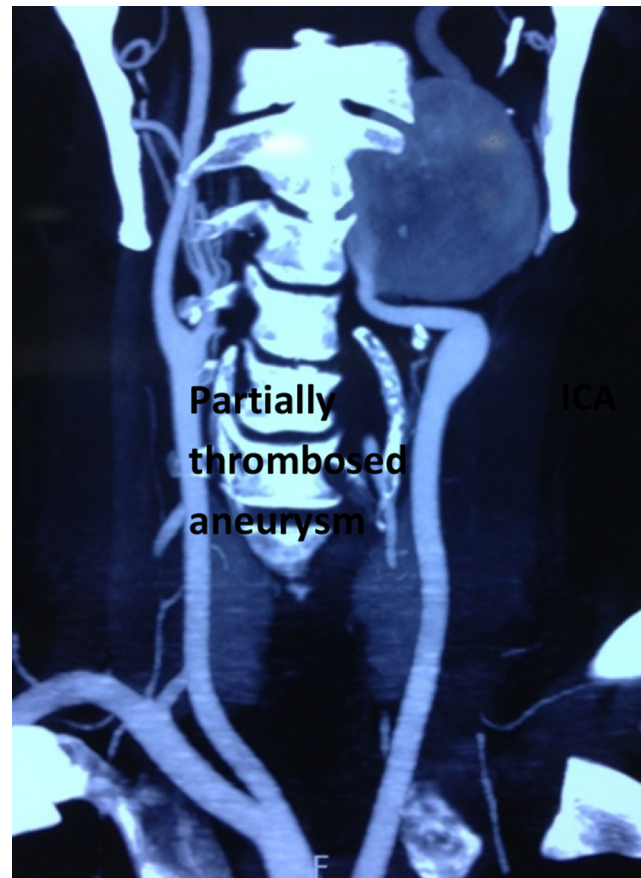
CT angiographic image of large left ICA aneurysm with highly tortuous and kinked ICA proximal and distal to the lesion.
